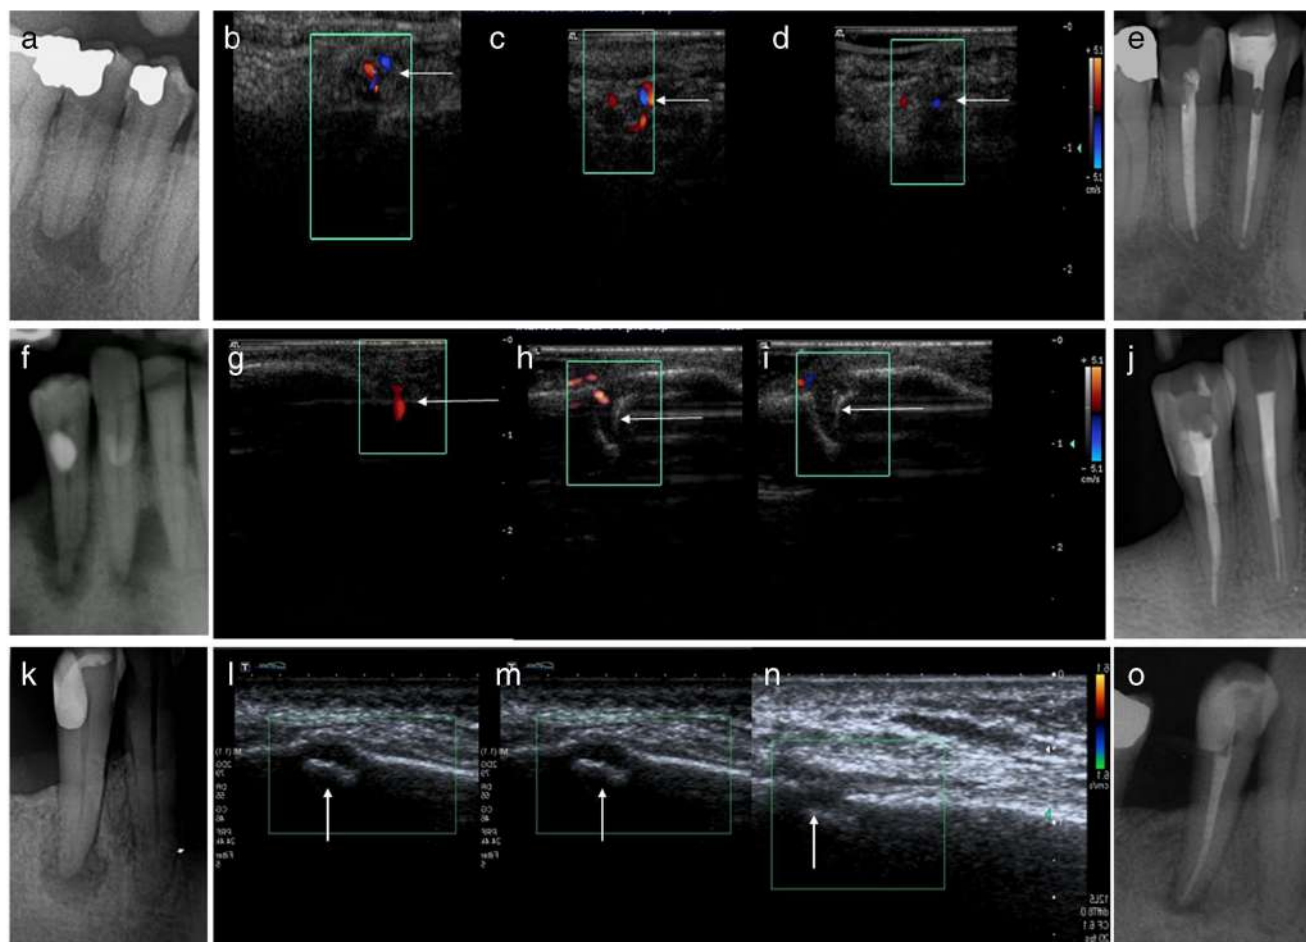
Cases no. 1 and 2. a Periapical radiograph showing two lesions on teeth no. 28 and no. 29. b Preoperative US-CPD showing vascularity within the lesions (*arrow*). c Intraoperative US-CPD showing no change in intra-lesional vascularity (*arrow*). d Postoperative US-CPD showing a reduction in intra-lesional vascularity (*arrow*). e Periapical radiograph showing healing of the lesions. Case number 4. f Periapical radiograph showing AP. g Preoperative US-CPD showing intra-lesional vascular flow (*arrow*). h US-CPD showing a disappearance of the intra-lesional
